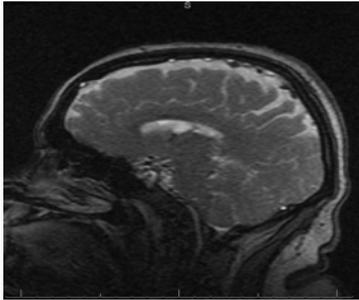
MRI image depicting restricted diffusion in corpus callosum.
